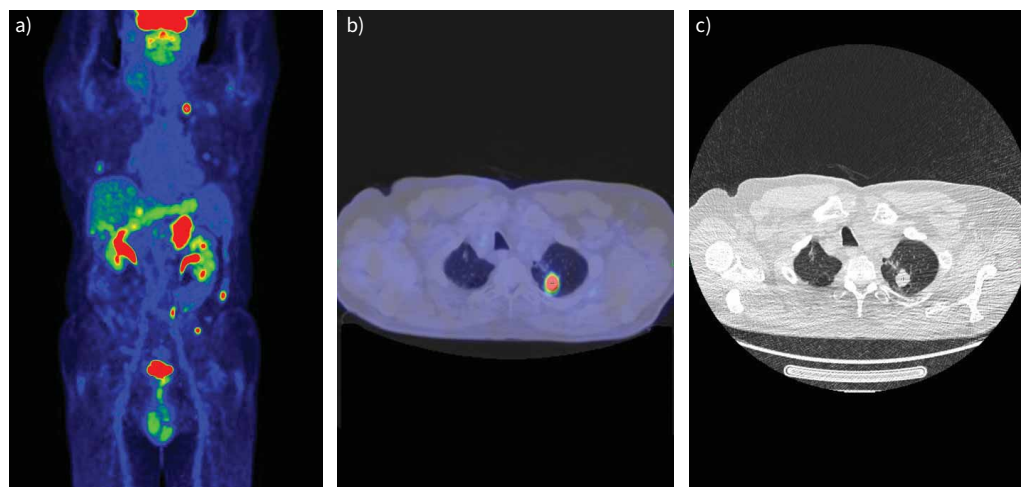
Staging of lung adenocarcinoma with 2-fluoro-2-deoxy-D-glucose positron emission tomography/computed tomography (FDG-PET/CT). a) PET image; b) fused image; c) chest CT. Images show the primary tumour in the left lung, multiple pulmonary inflammatory lesions and bilateral adrenal metastases.
